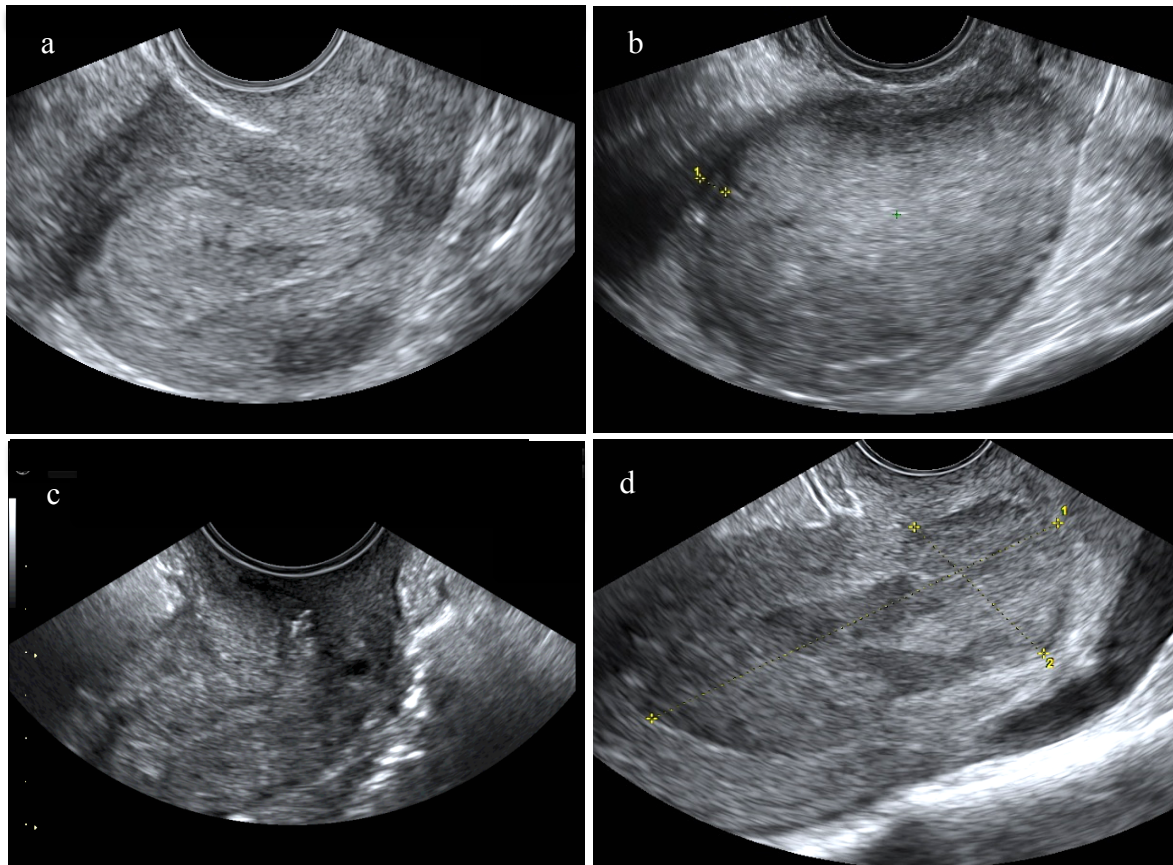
Ultrasound tumor measurements: a) the distance from the lower margin of the tumor to the outer cervical os in the sagittal plane, b) the anteroposterior (AP) uterine diameter, the AP tumor diameter (tumor thickness) and the craniocaudal tumor diameter (tumor length) in the sagittal plane, c) laterolateral uterine diameter (uterine width) and laterolateral tumor diameter (tumor width) in the transverse plane and d) minimal tumor-free margin to the serosa, measurable in any plane. Reprinted with permission<sup>66</sup>
